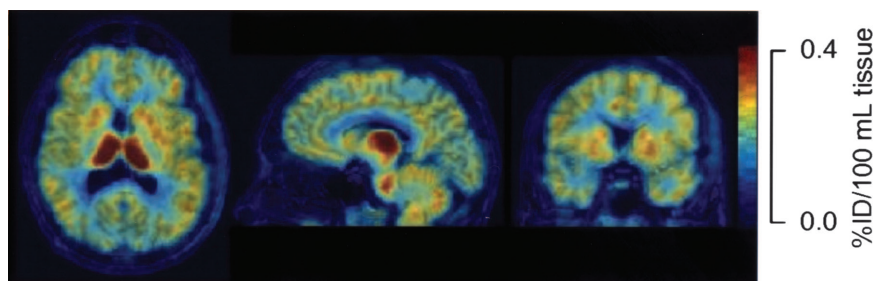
Axial, sagittal, and coronal mean PET images (from left to right) obtained between 60 and 120 min in 1 subject, after injection of 2-¹⁸F-fluoro-A-85380 (174 MBq). PET images are represented with coregistered MR images. %ID = percentage injected dose.
